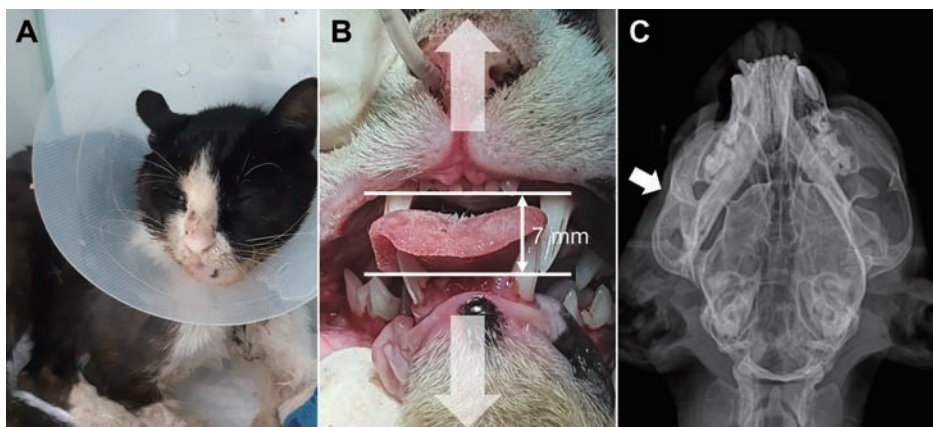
(A) The patient at the first visit, with poor hair condition and low body weight. (B) We attempted to manipulate the patient's mandible and maxilla in the direction indicated by the respective semi-transparent arrows, but neither opening nor closing occurred. The interincisor gap was 7 mm. (C) Ventrodorsal radiographic projection of the patient's skull. Abnormal osseous structure (arrow) around the right temporomandibular joint and the mandible displaced to the right were observed. In all three images, the left side of the pictures corresponds to the patient's right side.
